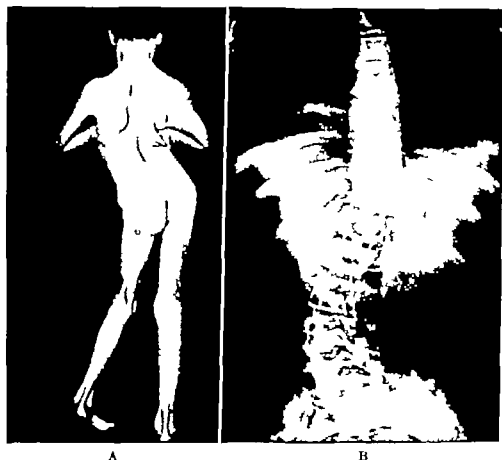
Scoliosis secondary to spastic paralysis A Patient in upright position B Roentgenogram of spine
